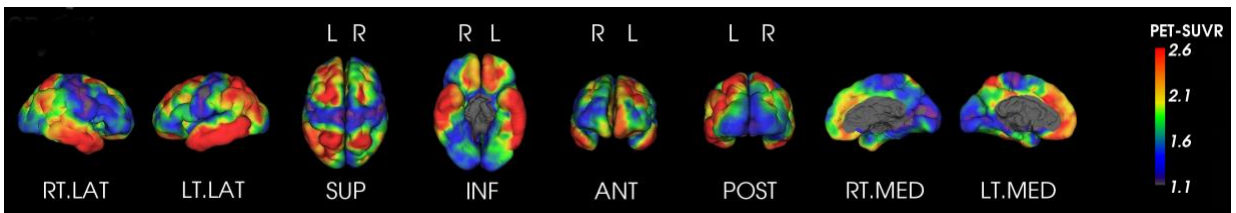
A positive ^{18}F -AV1451 scan displayed as stereotactic surface projection of SUVR using cerebellar grey matter as reference region.
